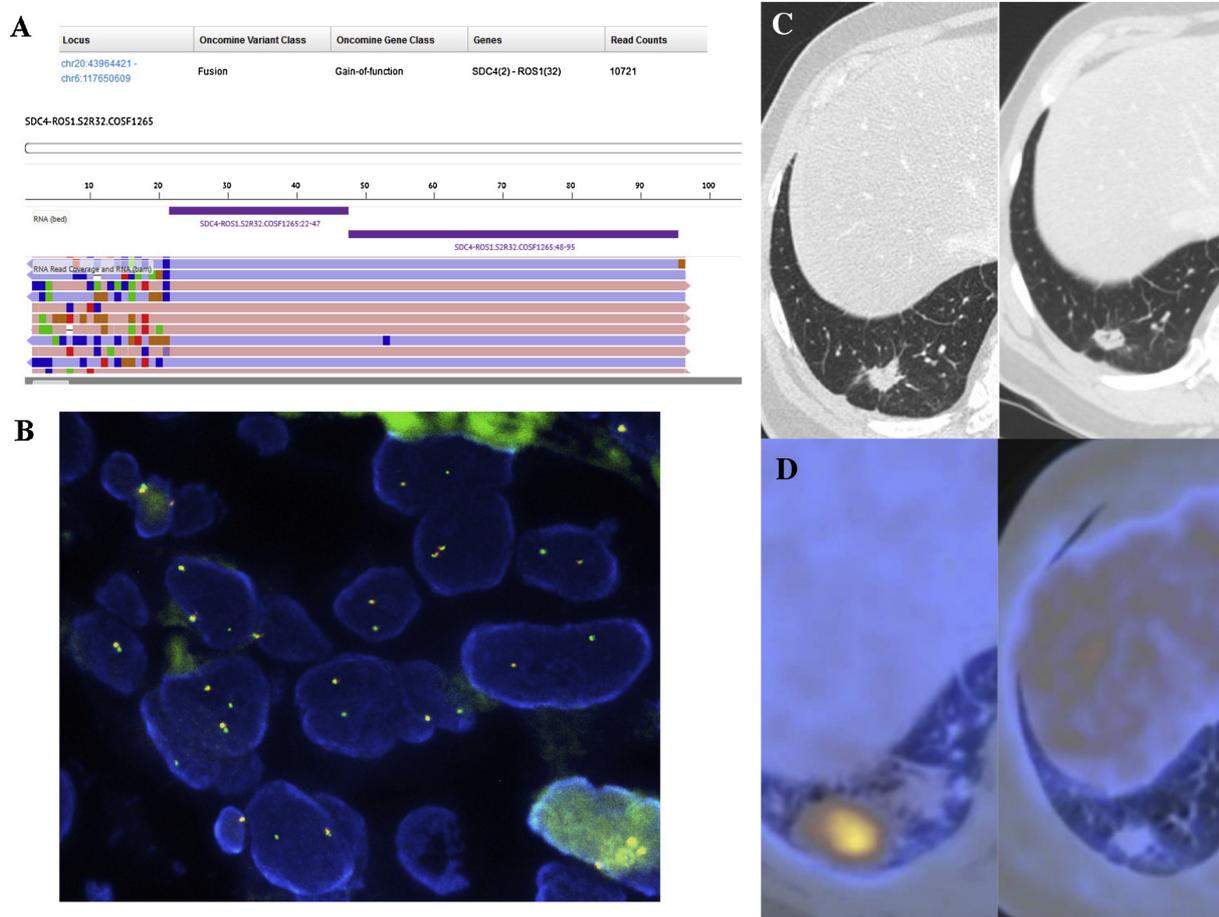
NGS and FISH results and response to therapy related to case #8: A) NGS analysis report describing the fusion of *ROS1* with *SDC4* (Ion Reporter software and IGV visualization); B) FISH image showing the 5' *ROS1* deletion pattern (DAPI 100X); C) CT and (D) PET scan before (first column) and after (second column) therapy with Crizotinib.
